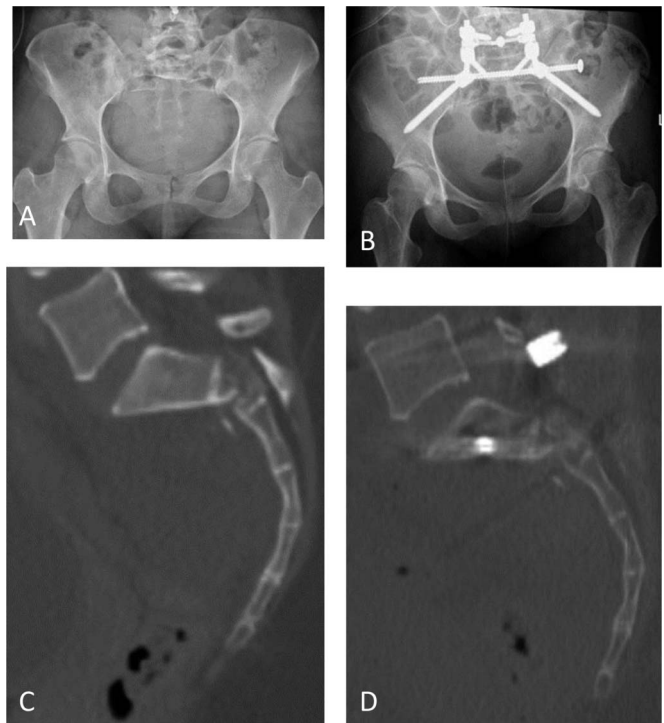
Preoperative (A) and postoperative (B) anteroposterior pelvic radiograph and preoperative (C) and postoperative (D) sagittal CT reconstruction demonstrating a patient with symphysis pubis disruption and bilateral sacral fractures with a S1-S2 transverse component with anterior translation and kyphosis of S1 in relation to S2. Postoperative imaging demonstrates overall improved alignment with less anterior translation and increased lordosis and safe juxtacortical transsacral screw placement.
